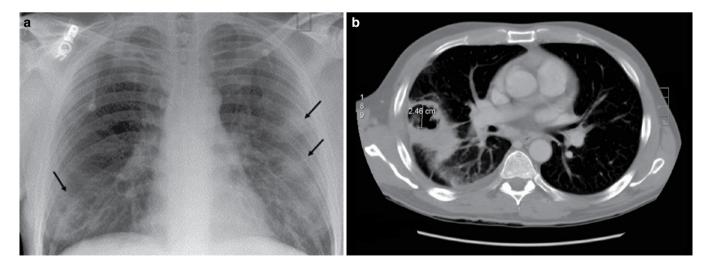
(a) Chest radiograph of a patient with vague infiltrate in the *right lower lobe*, which is more clearly identified in (b) the computerized tomographic (CT) scan.
